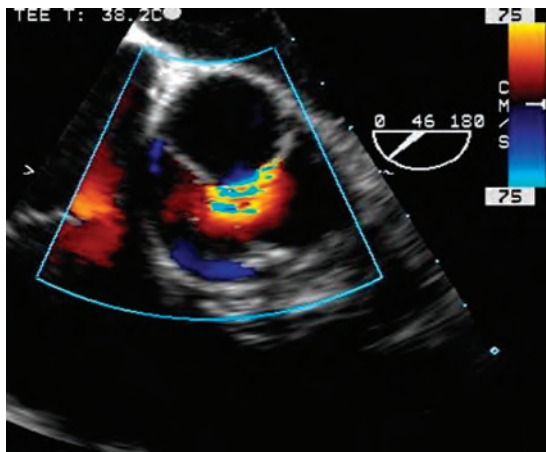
Midesophageal short-axis view of the aortic valve in diastole (imaging angle of 46 degrees). Color-flow Doppler imaging shows central commissural aortic regurgitation at the midpoint of the anterior cusp. This location of the regurgitation suggests focal prolapse of an aortic cusp. When considered together with the posterior eccentric flow evident in Fig. 23.55, the mechanism for the aortic regurgitation in this case is focal prolapse of the anterior cusp in the region of the raphe. This identification of this focal mechanism suggests the possibility of a focal aortic valve repair.
